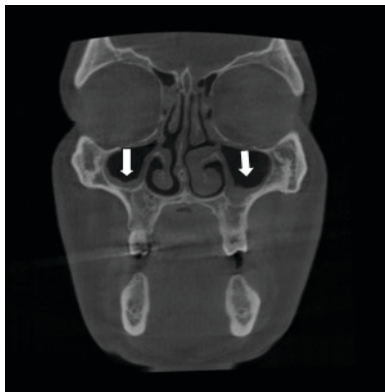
Coronal cross-section of the mucosal thickening of the right and left maxilla CBCT
